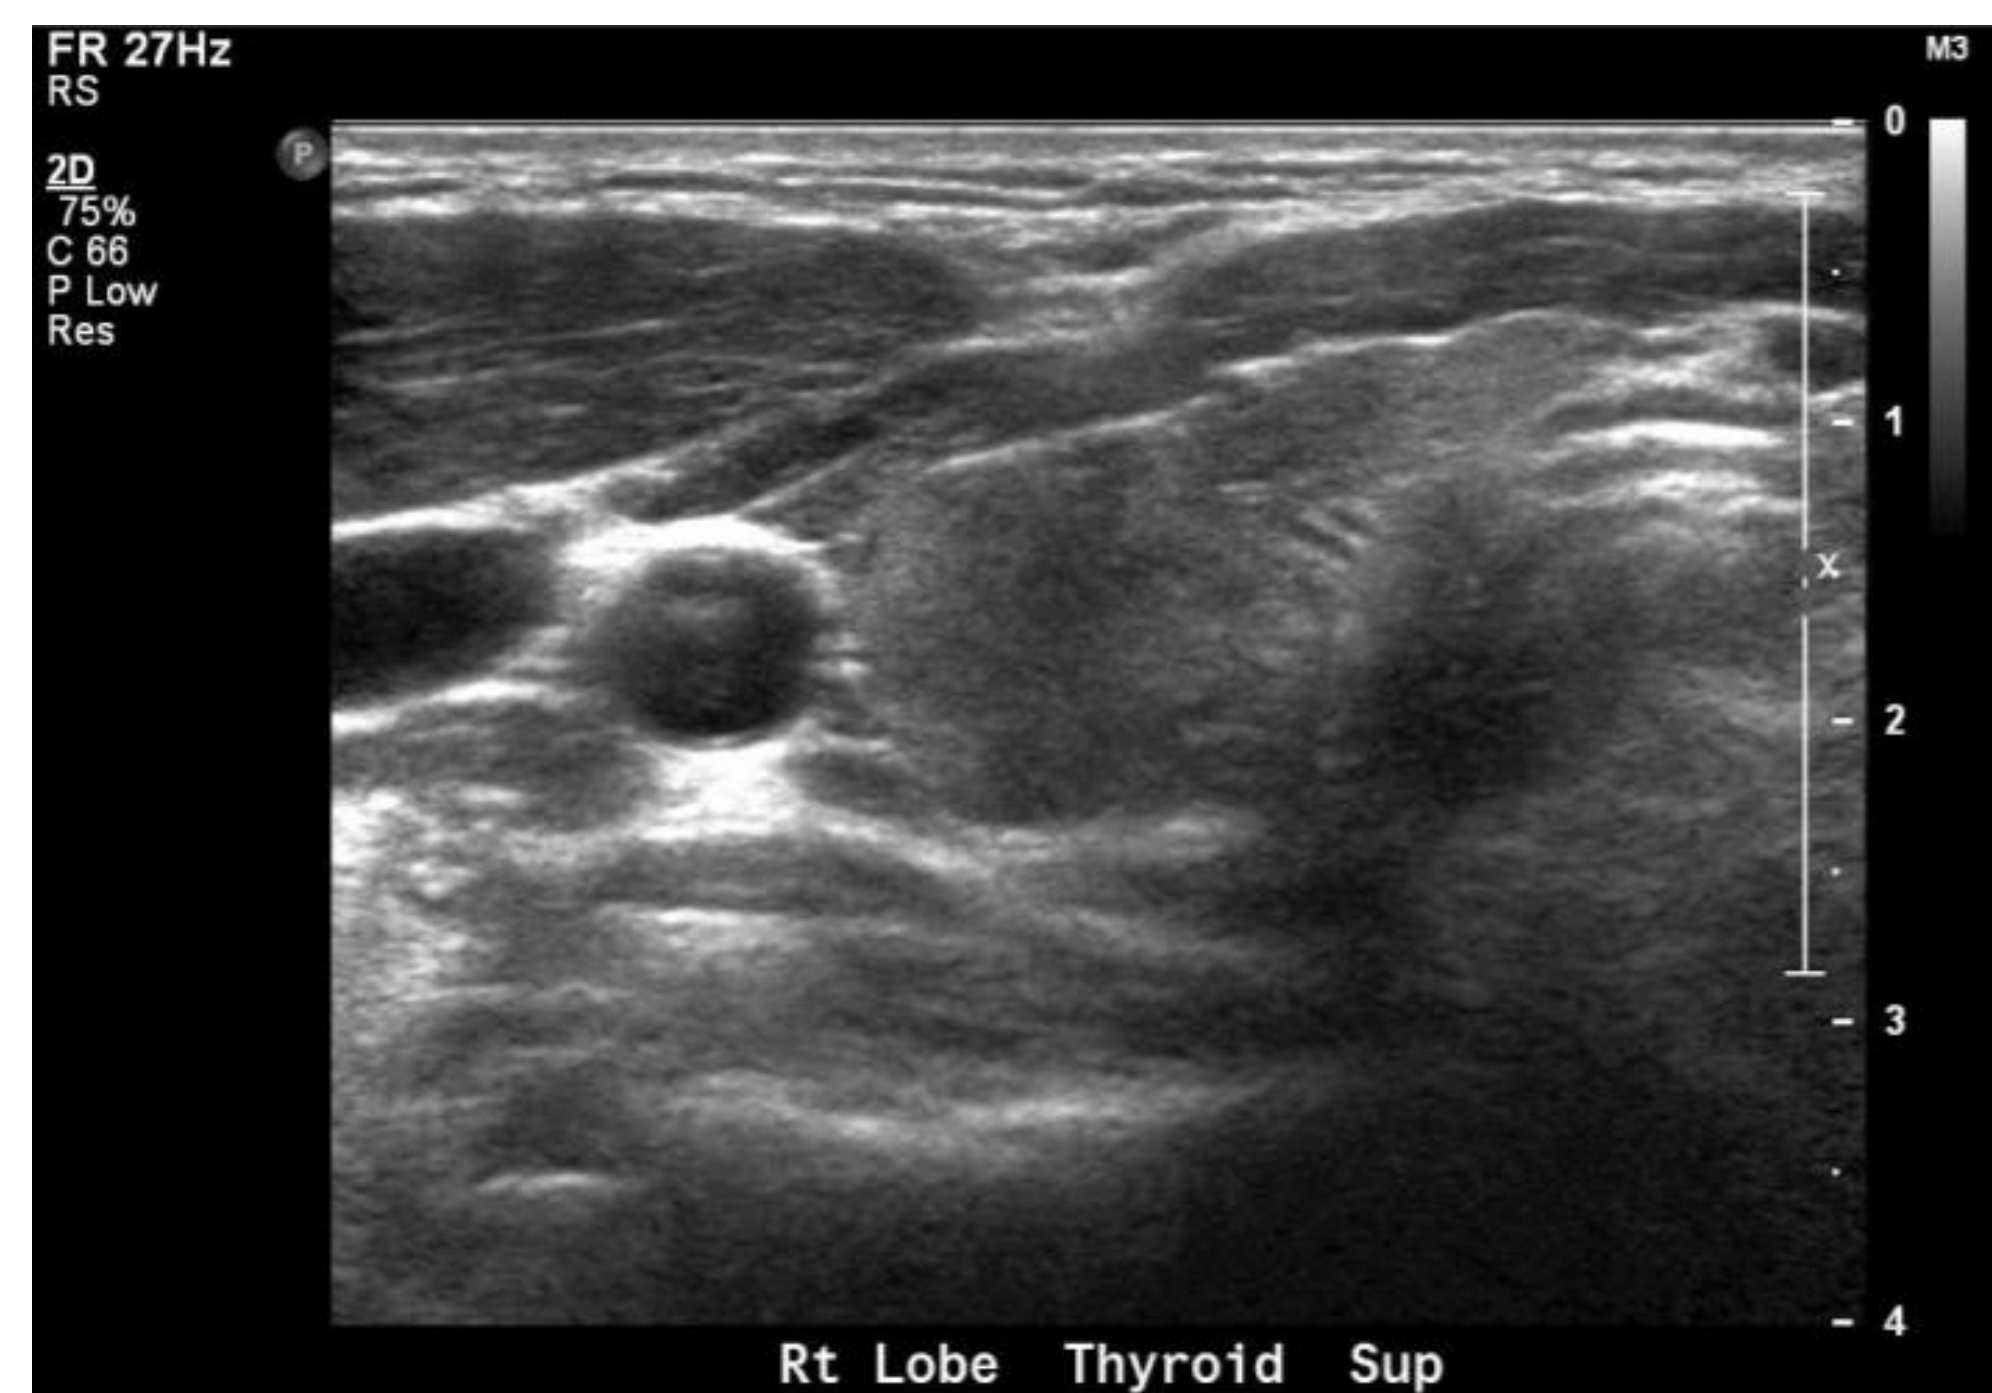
Thyroid ultrasound.
